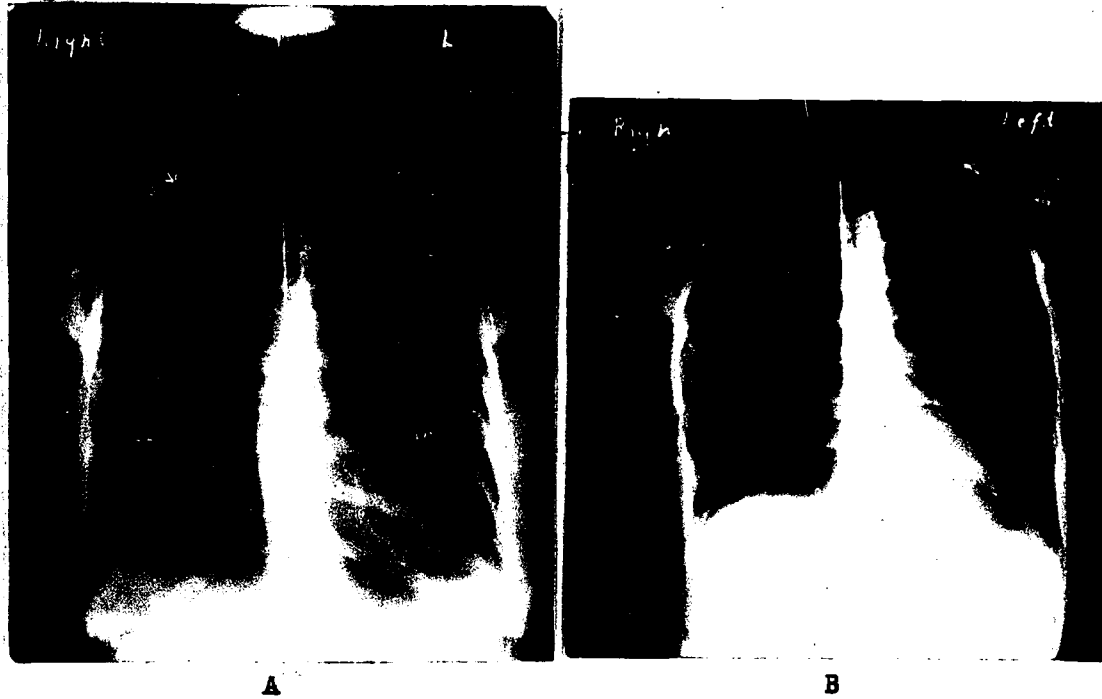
The shoulder girdle and upper thorax. A is a radiograph of the thorax in which the shoulder girdle and upper thorax are fairly symmetrical; B is one in which both structures are higher on the left side.
